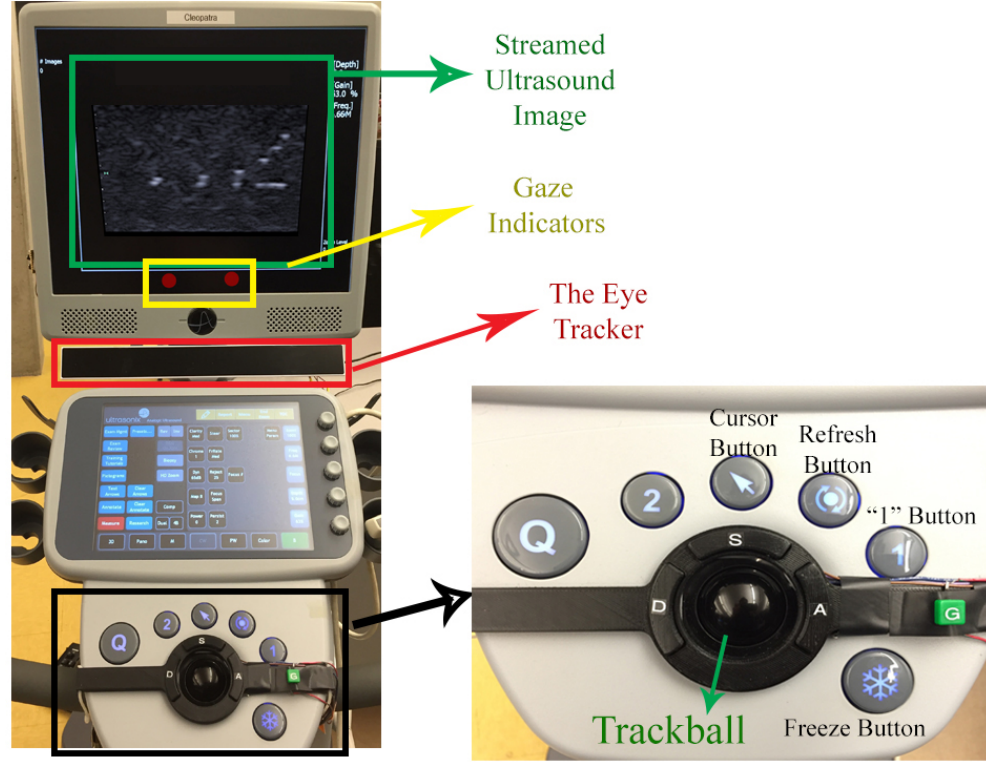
The Ultrasound Machine and System Components Used for the Implementation of Our Systems and User Study (Left). The Control Keys Panel of the Ultrasound Machine Used in Our Users Study (Right).
